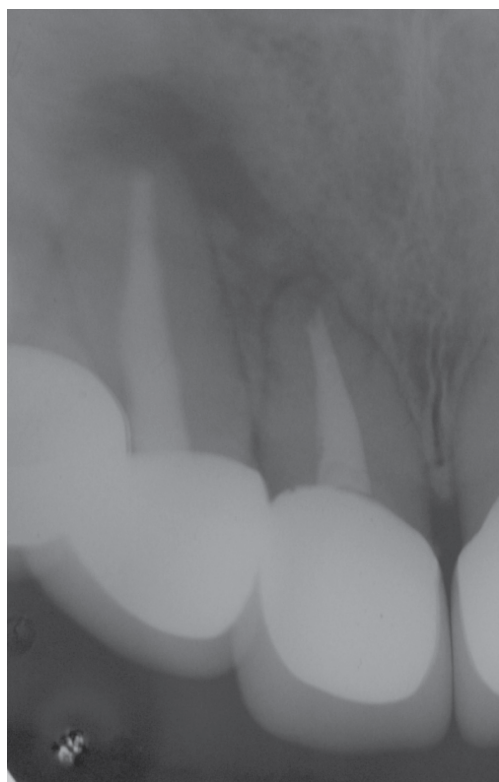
Five-month postoperative radiograph showing periapical healing.
